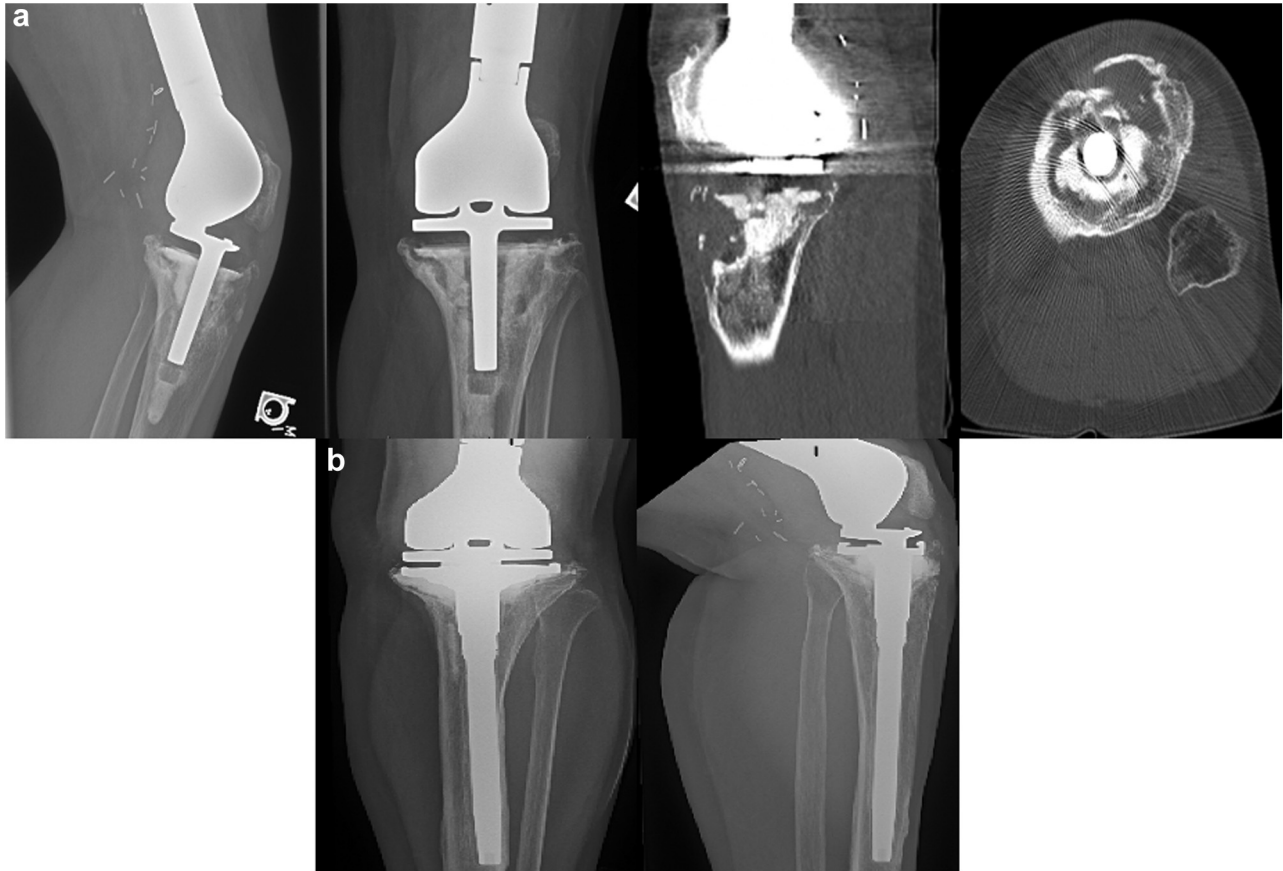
Patient A, left knee. (a) Repeat plain radiograph and CT images demonstrating progression of the osteolytic lesion and break of the cement mantle of the tibial component at 6 y after the initial revision. (b) Plain radiographs 6 y after curettage of the granuloma, revision of the all-polyethylene tibial component to a long press-fit stem with a cemented base plate, and impact grafting of the proximal tibia. Although radiographic findings suggestive of loosening of the tibial stem were observed, these radiographic changes have remained stable since the all-polyethylene tibia revision, and the patient remained asymptomatic.
